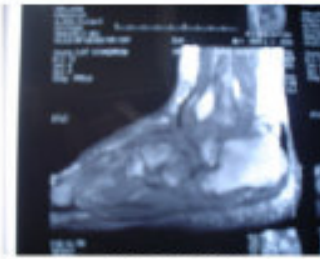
MRI, T1 W. images: Osteomyelitis of anterior part of the calcaneus with cellulites.
